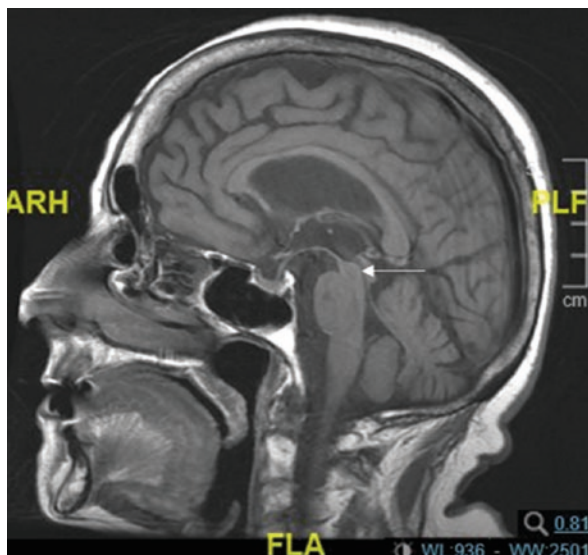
In general, neuroimaging studies are not particularly helpful in the diagnosis of parkinsonism. In this patient with multisystem atrophy, however, brain MRI shows (a) atrophy of the pons and cerebellum on sagittal view and (b) the pathognomonic “hot cross bun” sign in the pons on axial view
